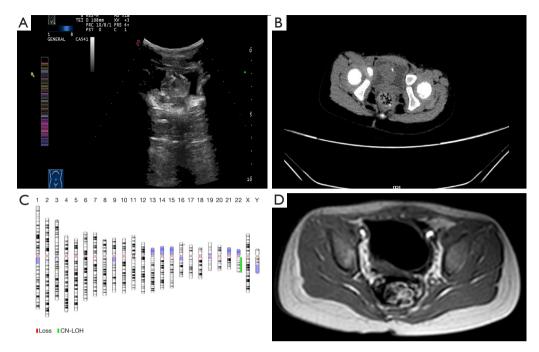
Imaging and genetic analysis of the bladder tumor in a 4-year-old patient. (A) Bladder US reveals the presence of an intravesical mass. (B) CT imaging shows an irregular mass within the bladder, with relatively well-defined margins and a size of approximately 28 mm × 25 mm × 20 mm. (C) The gene chip testing results revealed the presence of a heterozygous deletion in the *SMARCB1* gene. (D) Post-treatment MRI reveals no signs of recurrence 15 months after the initial surgery and chemotherapy. CN-LOH, copy neutral loss of heterozygosity; US, ultrasound; CT, computed tomography; MRI, magnetic resonance imaging.
